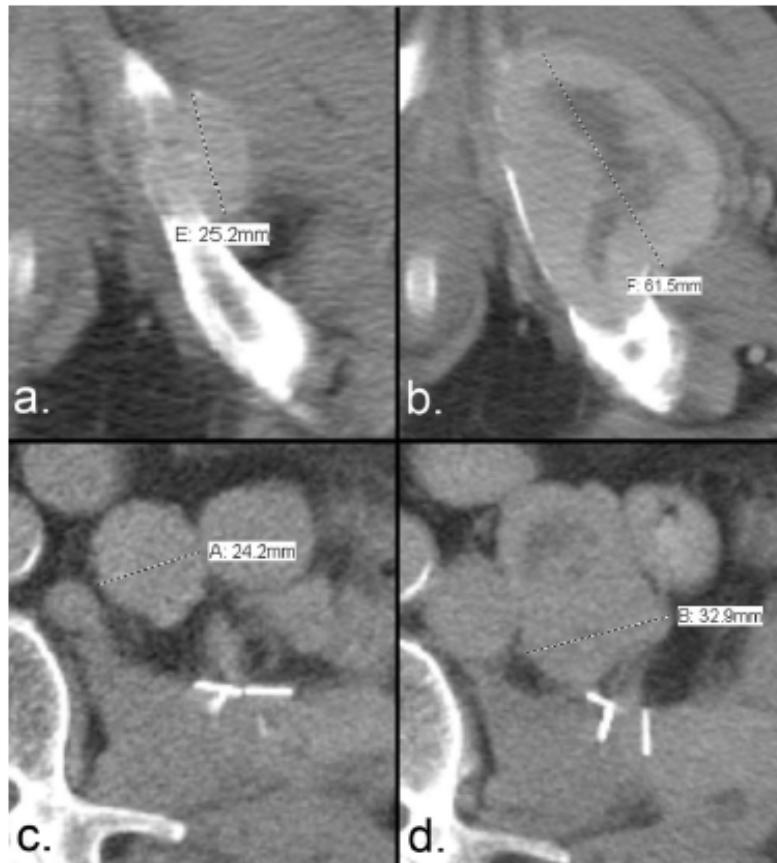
Measurement of disease progression using the RECIST 1.1 criteria. (a) Axial CT of the pelvis and abdomen of a patient with renal cell carcinoma demonstrates a bone metastasis in the left inferior pubic ramus. The soft tissue component is > 10 mm, and (b) the short-axis diameter of the left retroperitoneal lymph node metastasis is > 15 mm; both are considered measurable according to RECIST 1.1. The sum of the longest diameters is used to assess tumor response. (c) The bone metastasis has increased from 25.2 mm to 61.5 mm, and (d) the nodal metastasis has increased from 24.2 mm to 32.9 mm. The sum of the 2 lesions at the first time point is 49.4 mm, and the sum at the second time point is 94.4 mm. This increase of 91% exceeds the required $> 20\%$ increase that is necessary to qualify for the progressive disease category.
